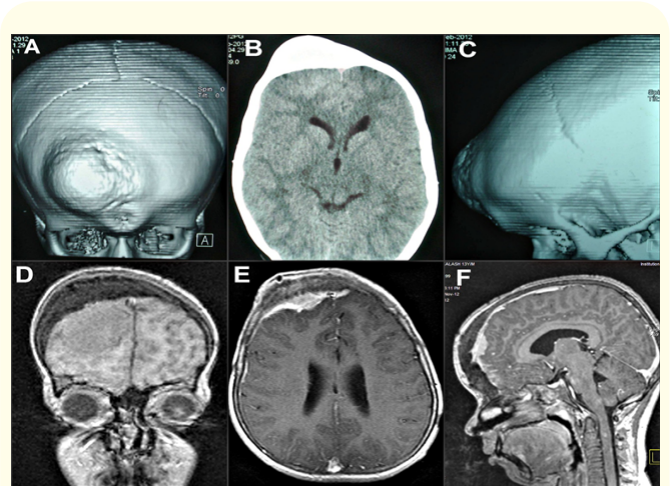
(A, B, C) Plain, non-contrast enhanced cranial/cerebral CT scans, using 5mm serial contiguous sections revealed a bony hyperdense outgrowth arising from the right frontal bone with no obvious intracranial extension. (D, E, F) Pre- and Post- contrasted cranial/ cerebral Magnetic Resonance Imaging showed a homogeneous, hypodense expansion of the right frontal bone, with no evidence of intracranial extension. However, a dural reaction is evident adjacent to the intradiploeic lesion.
